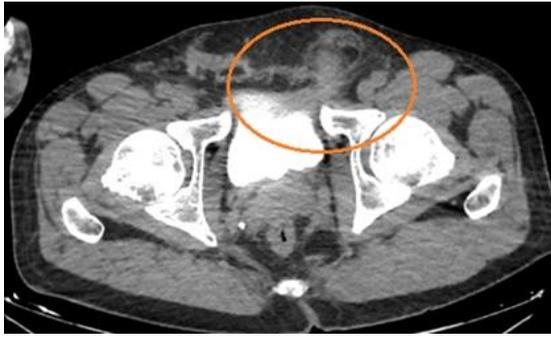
The marked area shows the herniated area on CT
